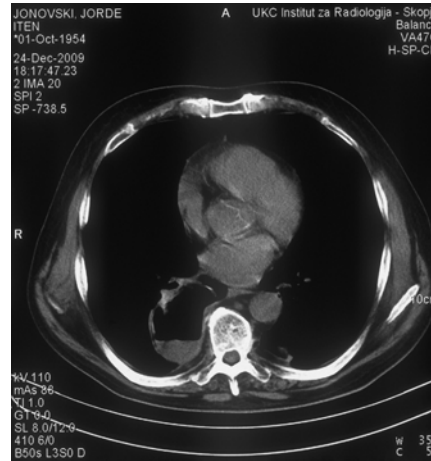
Large excavated pulmonary granuloma on chest CT
